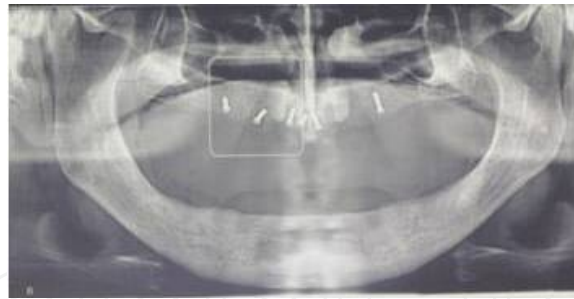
Post-operative panoramic radiograph of the graft
